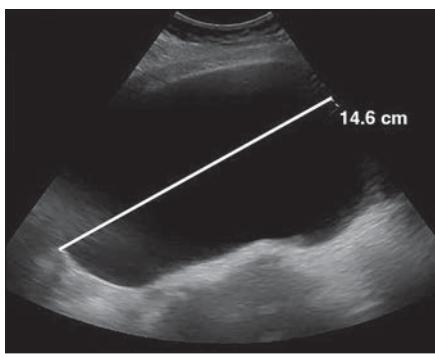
25-year-old woman with adnexal lesion. A, Transabdominal gray-scale ultrasound (US) image shows simple-appearing cyst measuring 14.6 cm (line). Visualized portions show no obvious solid components. Cyst was classified as Ovarian-Adnexal Reporting and Data System (O-RADS) US category 0 because of size and reverberation artifact along right lateral and anterior portions of lesion. MRI was performed 2 weeks after ultrasound.
